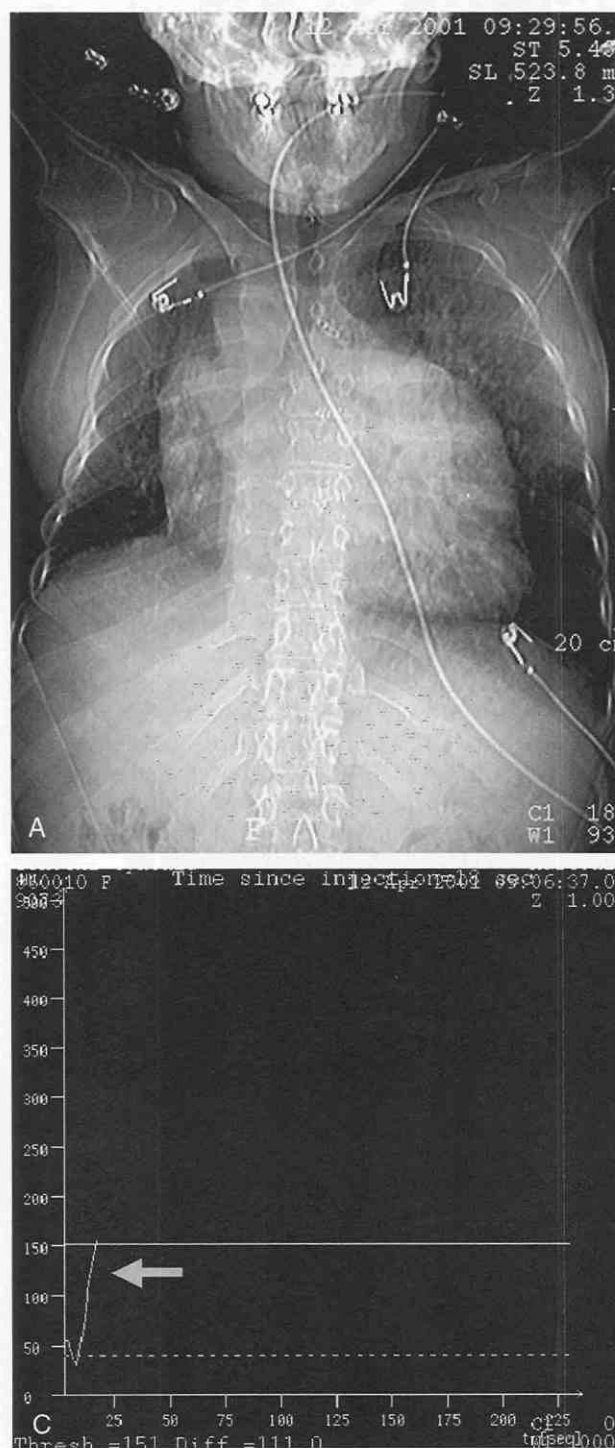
A, CT tomogram of a young patient with complex congenital heart disease. There is significant cardiomegaly and a right aortic arch. Using an empiric delay for contrast injection would be inappropriate in this clinical setting. B, Axial scan demonstrating an automated bolus tracking technique shows the region of interest drawn in the ascending aorta to optimize contrast visualization. C, Automated bolus tracking technique for optimizing intravenous injection of contrast material. Arrow denotes the time to optimal contrast enhancement of the ascending aorta.
